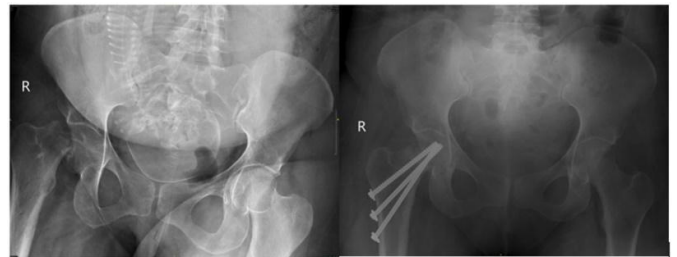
pre-operative and post-operative plain radiograph showing fracture at subcapital right neck of femur
